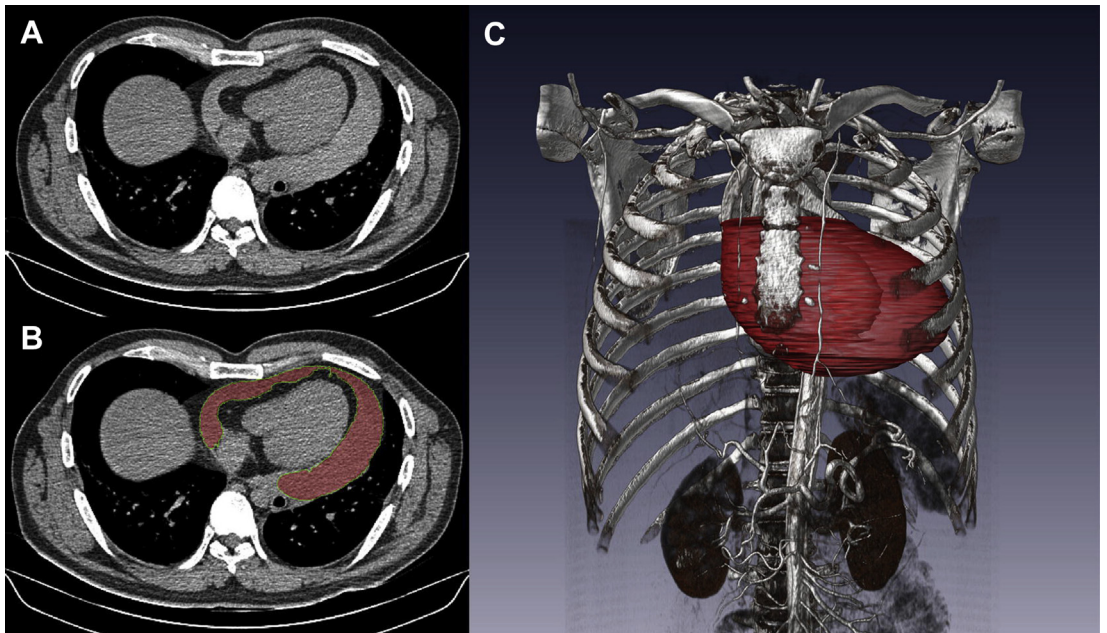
(A) Volume measurement by segmentation using axial CT images. (B) Pericardial effusion is marked manually for each slice or resampled slices. (C) 3-D reconstruction of segmented pericardial effusion. (From Ebert LC, Ampanozi G, Ruder TD, et al. CT based volume measurement and estimation in cases of pericardial effusion. *J Forensic Legal Med* 2012;19:127; with permission.)
